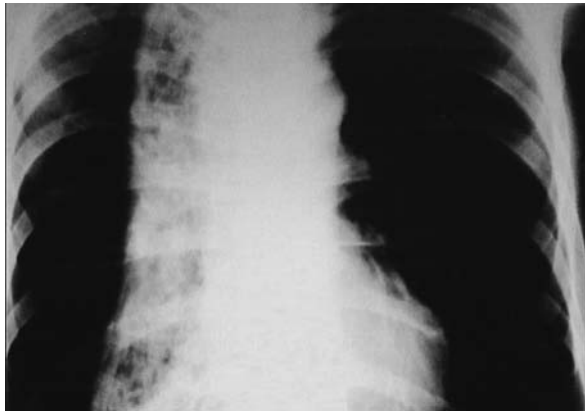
Mediastinal enlargement in chest X-ray
